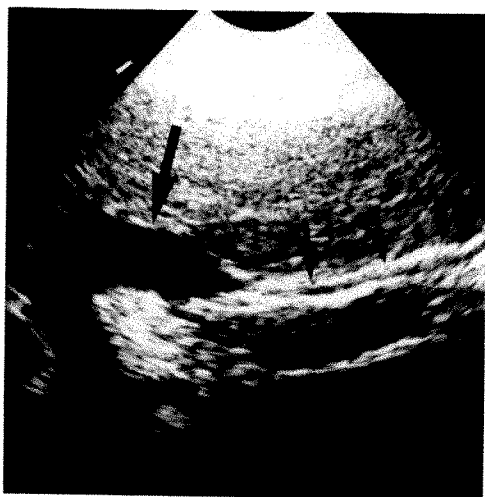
Longitudinal sonogram in a normal subject shows ligamentum teres (small arrows) coursing anteroinferiorly from umbilical portion of left portal vein (large arrow). Ligamentum teres in this case contains an apparent vessel (i.e., hypoechoic channel) from which no Doppler signal was obtained.
